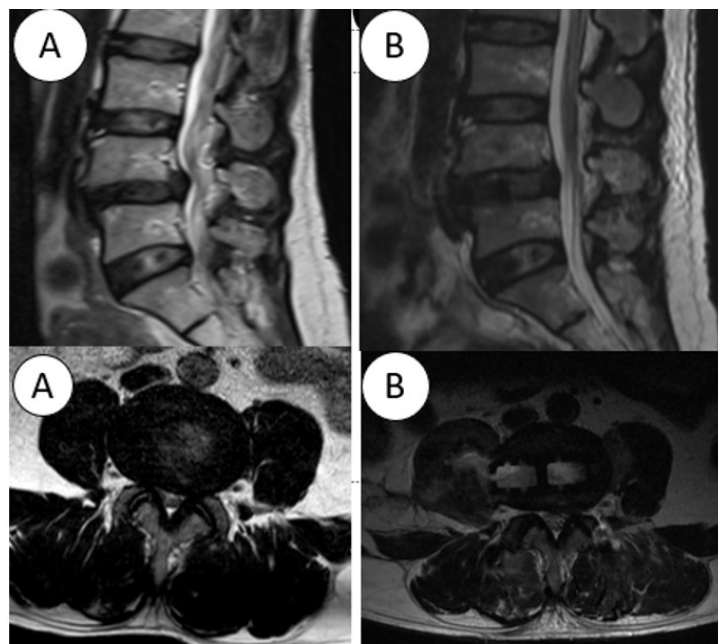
MRI before (A) and after (B) surgery.
